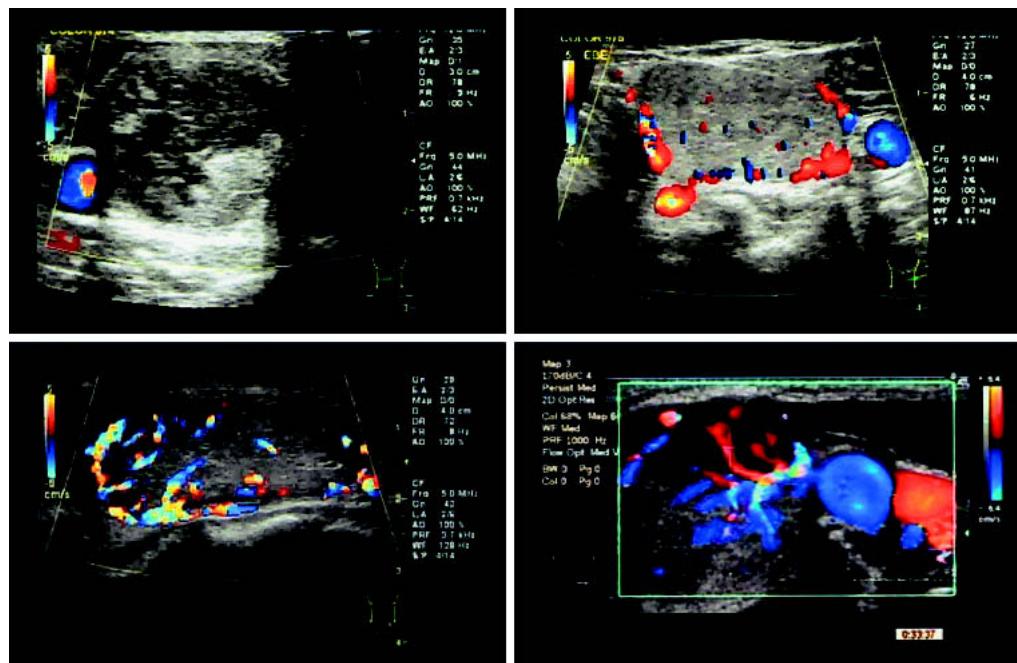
Characteristic color Doppler (CD) images of lesions with different grading scores (top left). Grade 1: There is no color flow mapping (CFM) inside the nodule (top right). Grade 2: CFM is seen only in the peripheral area (bottom left). Grade 3: blood flow penetrates the tumor, and vascularity was judged to be moderate (bottom right). Grade 4: several sources of blood flow penetrate the tumor, and vascularity was judged to be rich. Blood flow analysis revealed high-velocity flow and pulsating feeding vessels with a pulsatility index (PI) of > 1.0.
